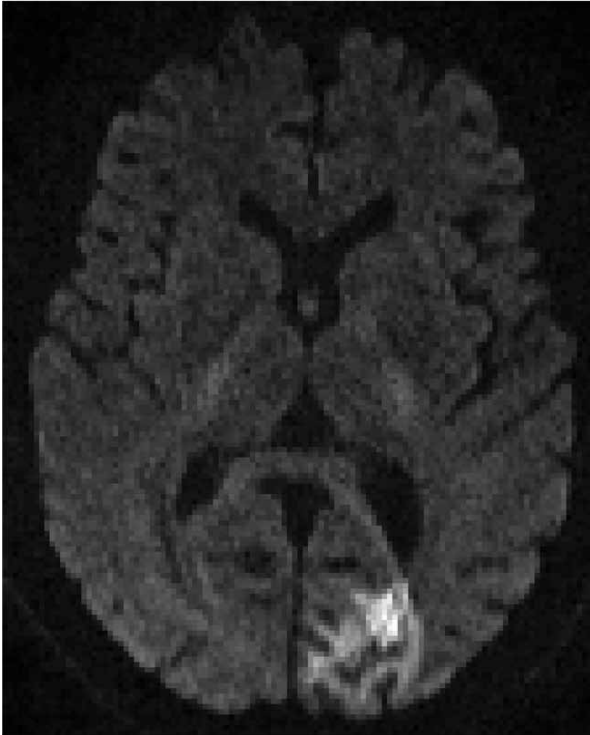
Axial diffusion-weighted MR imaging reveals acute infarction in the left occipital lobe.
